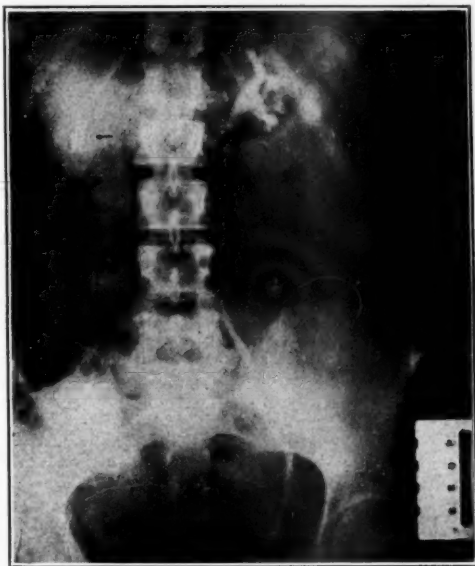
Showing a rather large left kidney shadow with apparently normal pelvis and calices. Left ureteral lumen about normal, but the original film shows two definitely narrowed areas, one in the iliac gland region and one in the juxtavesical region. These x-ray narrowings correspond to two areas of hang obtained by the dilating bulb. Note the rather long liver lappet. Right kidney shadow small. An irregular shadow in lower pole region measuring about 4 cm. by 15 mm., apparently made up of numerous small porous stone shadows. This appearance together with the position relative to the liver aroused suspicion of possible gallstones.
